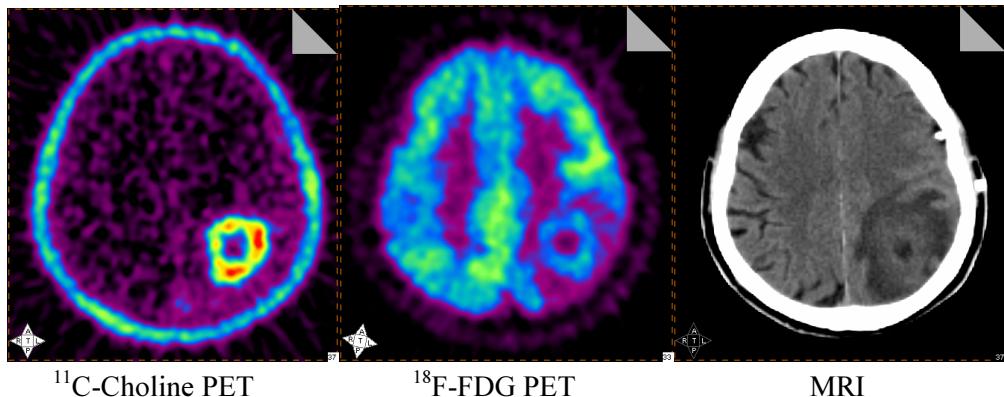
A 63-year-old male presented with right-sided weakness and decreased response for 10 days. MRI showed a mass in left parietal lobe. The Choline and FDG PET scan showed hypometabolism in the whole left parietal lobe except moderate uptakes forming a “ring” sign correlated to the enhanced foci on MRI images. The pathology was abscess.
